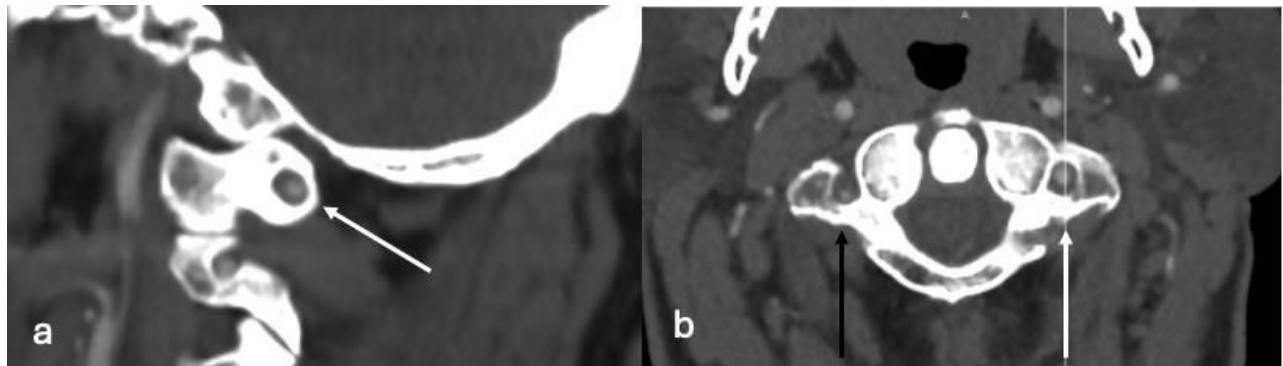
(a, b) Computed tomography images demonstrating a complete left-sided Ponticulus posticus anomaly (white arrows); (b) Contralateral right-sided vertebral artery hypoplasia (black arrow).
